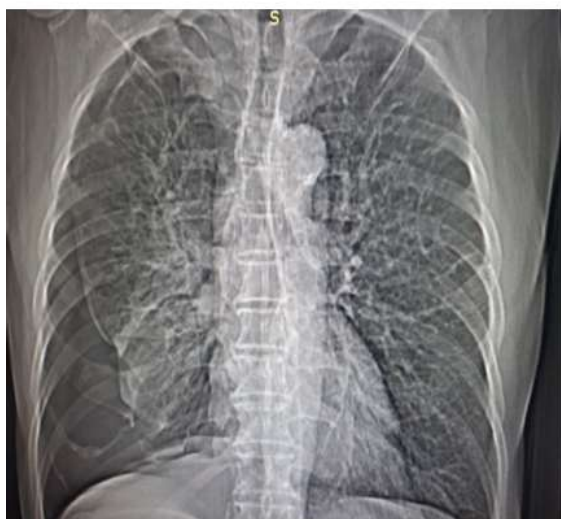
Chest radiography large right pnx
